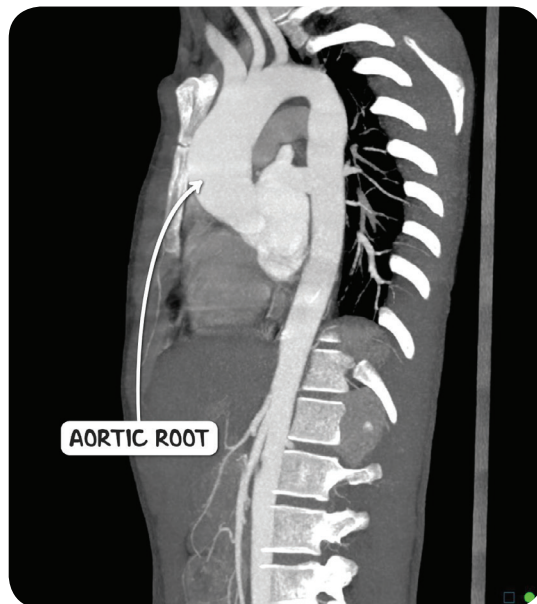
A contrast CT scan of the chest in the sagittal plane demonstrating aortic root dilation in an individual with Marfan syndrome.
